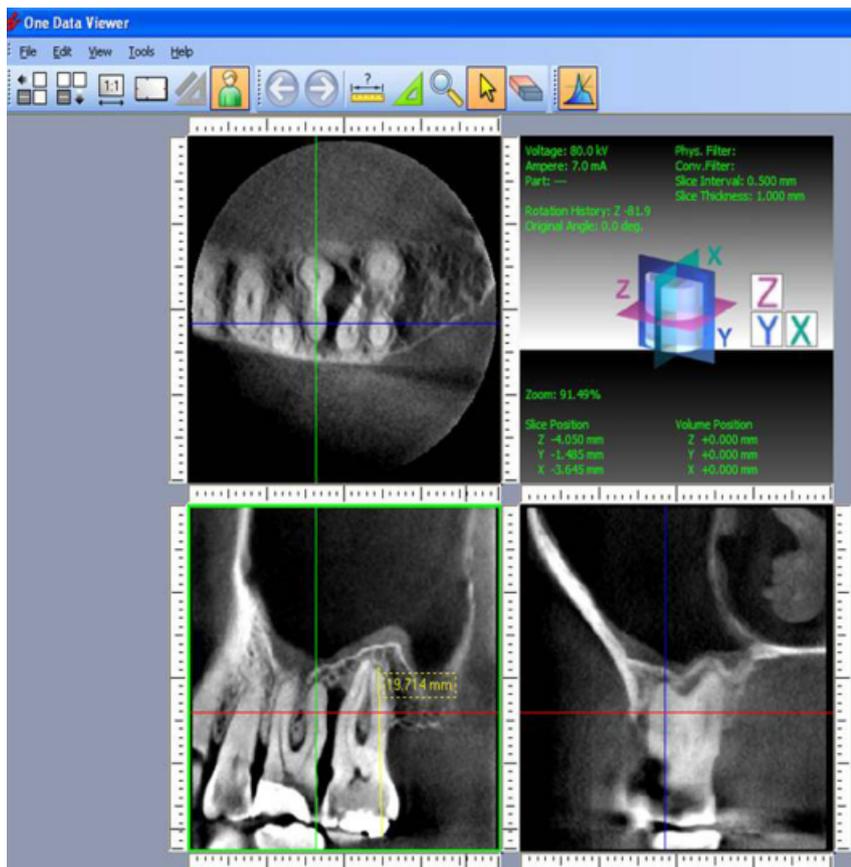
Cone beam computed tomography (CBCT) with horizontal, sagittal and transversal sections of first and second left maxillary molars (subject no. 8).
